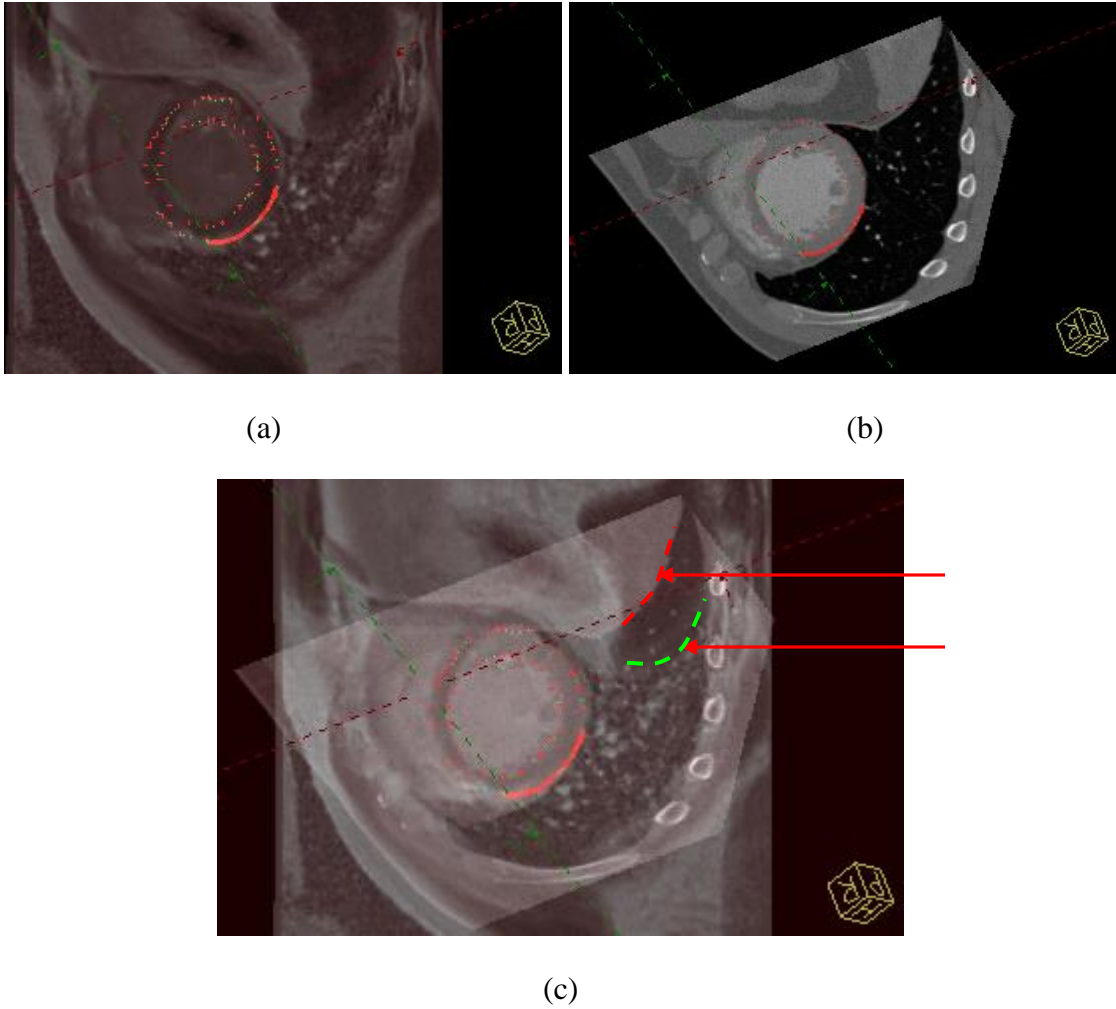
Orientation of images for Patient 6 after principal component analysis and before registration with thin plate spline and mutual information; DEMR (a), CTA (b) and overlay of both images in the short axis view (c). Arrows in (c) indicate the end of lung region in CTA (dashed red line) and DEMR (dashed green line).
